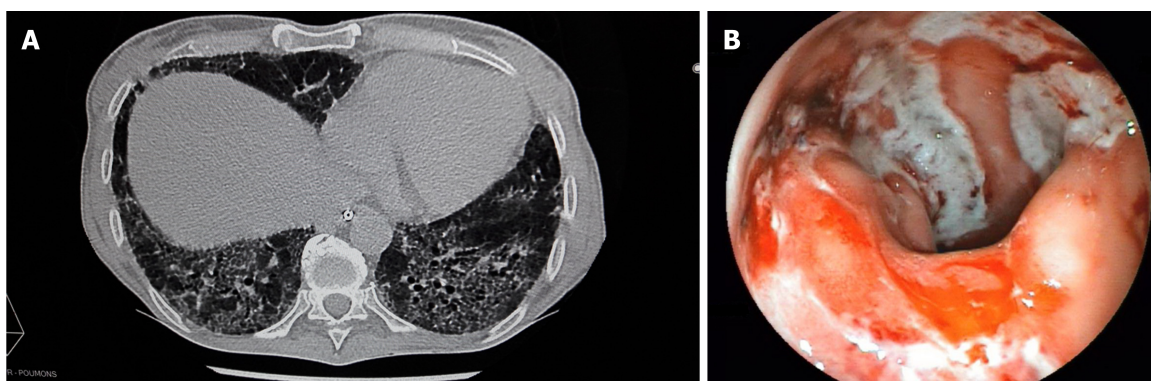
Computed tomography scan and sigmoidoscopy performed just after the patient's admission to the Gastroenterology Intensive Care Unit. A: Chest computed tomography scan demonstrating an old and severe bilateral pulmonary fibrosis; B: Sigmoidoscopy showing active bleeding colitis with edema, erythema and linear deep ulcerations.
